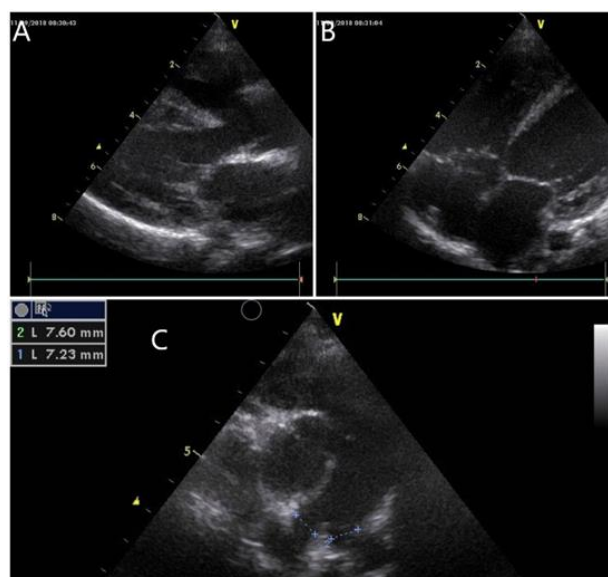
Echocardiographic evaluation on 1-year age, revealing almost completely regressed cardiac rhabdomyoma masses (A,B) and increased pulmonary artery size (C).
